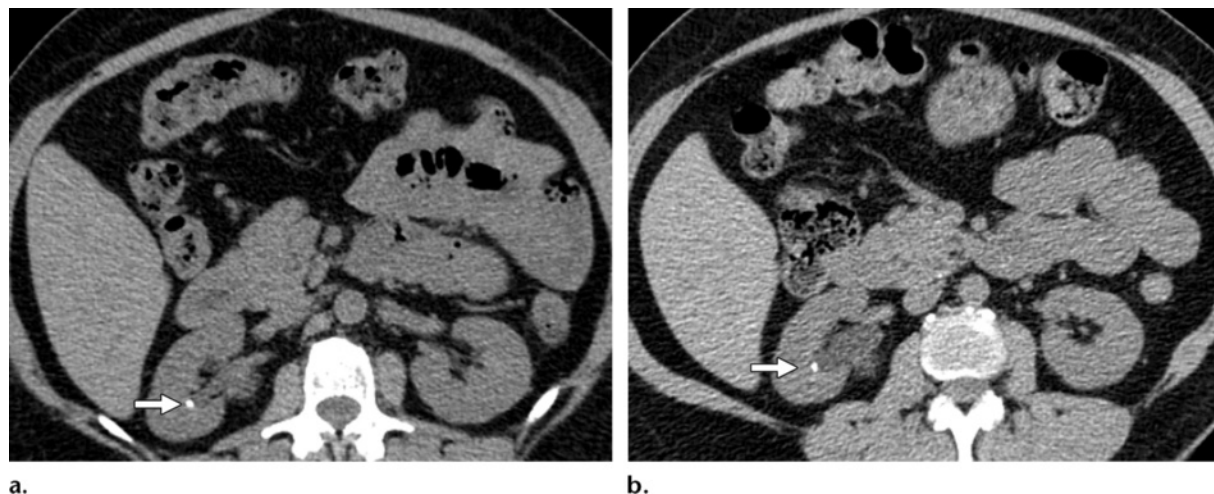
Benefits of reduced tube voltage for a 55-year-old man with a right midpole renal calculus. (a) Axial unenhanced CT scan (120 kVp, 240 mAs) shows the renal calculus (arrow). (b) Follow-up CT scan (100 kVp, 100 mAs) allows confident diagnosis of the renal calculus (arrow) in spite of increased noise in the image.
